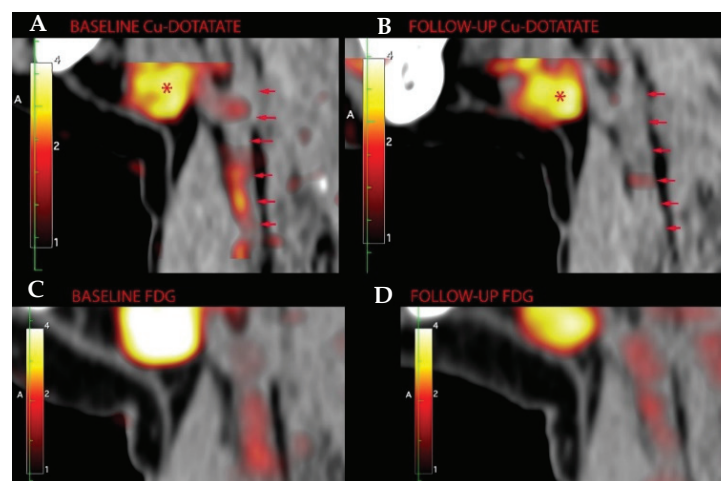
Sagittal $[^{64}\text{Cu}]\text{DOTATATE}$ -PET/CT images from a participant treated with liraglutide. The left carotid artery is outlined at (A) baseline ($\text{SUV}_{\text{mean}} = 1.2$) and (B) follow-up examination ($\text{SUV}_{\text{mean}} = 0.92$). * Physiological uptake in submandibular gland. The lower panels show $[^{18}\text{F}]\text{FDG}$ uptake from the same participant for comparison at (C) baseline and (D) follow-up.
